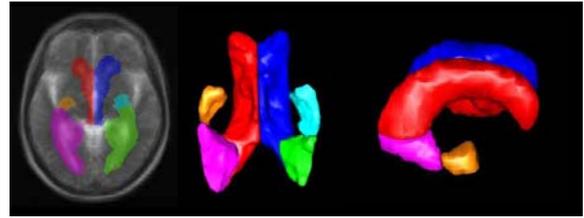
Manual definition of 6 ventricular areas on an average T2-weighted image. See Table 1 for description
